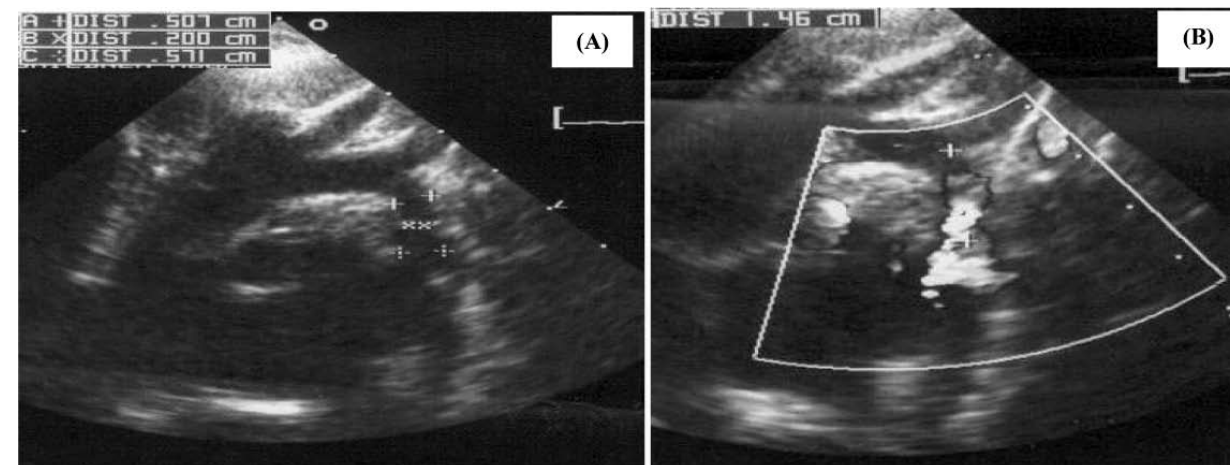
Echocardiography of aortic coarctation showing the diameter and length of coarctation area (A) & (B) respectively.
